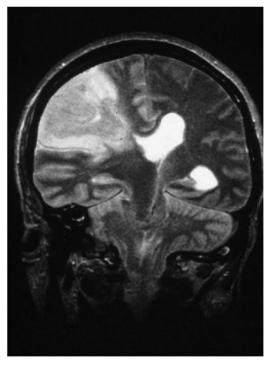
MRI showing a large right middle cerebral artery stroke with brain swelling that rerquired treatment with hyperosmolar therapy.
